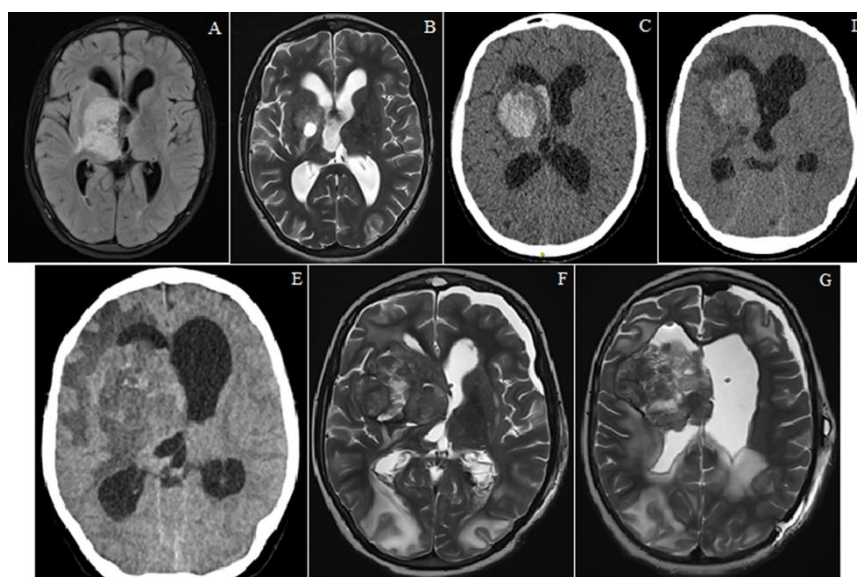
Evolution of imaging of the patient. A: axial T2-FLAIR MRI performed 5 months after the second surgery in 2019 and before proton-beam treatment. B: axial T2 MRI after proton-beam radiation. C: axial CT scan showing intratumoral hemorrhage in November 2020. D: axial CT scan revealing growth of the lesion and hydrocephalus in January 2021. E: axial CT scan performed because of clinical deterioration after the first VP shunt was implanted. F and G: axial T2 MRI from the last brain imaging test that was performed to the patient. It shows the growth and heterogeneity of the tumor, a decrease in the size of the lateral ventricles, and the hyperintense signal on the occipital lobes, compatible with posterior reversible encephalopathy syndrome.
